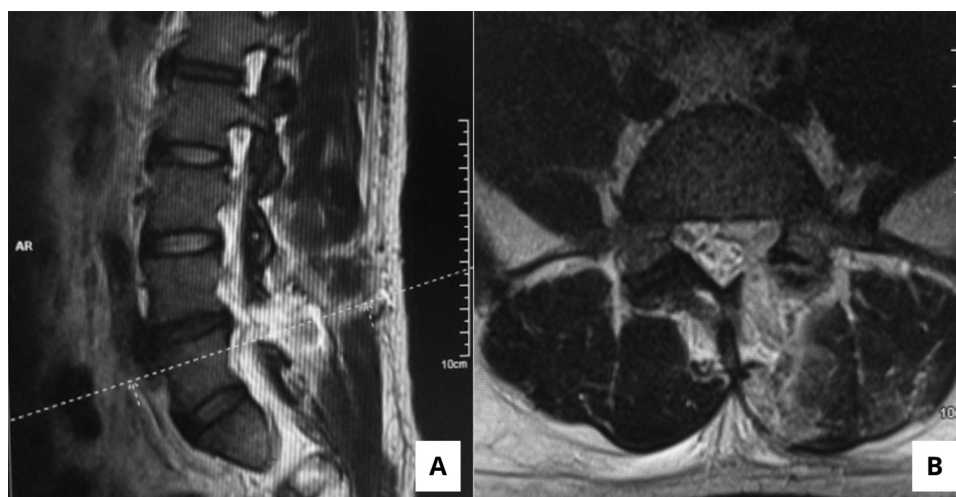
Preoperative magnetic resonance imaging (MRI) showing a facet cyst in level L4-L5 (A) sagittal view. The white dot line serves as a marker indicating the L4 vertebral level (B) axial view.
